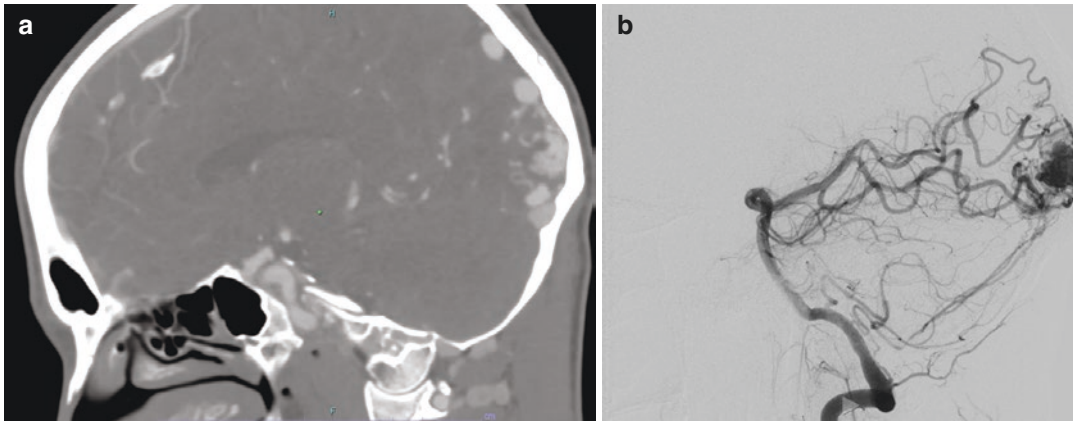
(a) CT angiogram demonstrating an occipital AVM. (b) Conventional DSA showing the same occipital AVM
